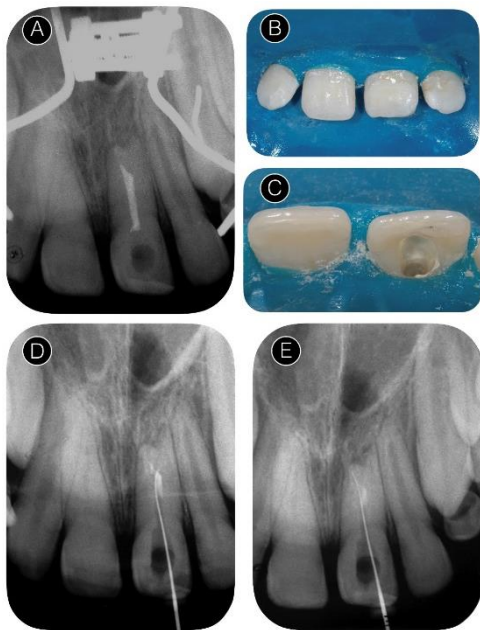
(A) Initial auxiliary diagnostic periapical radiograph. (B, C) Modified rubber dam isolation. (D, E) Identification of residual obturation material in the bifurcation region.
